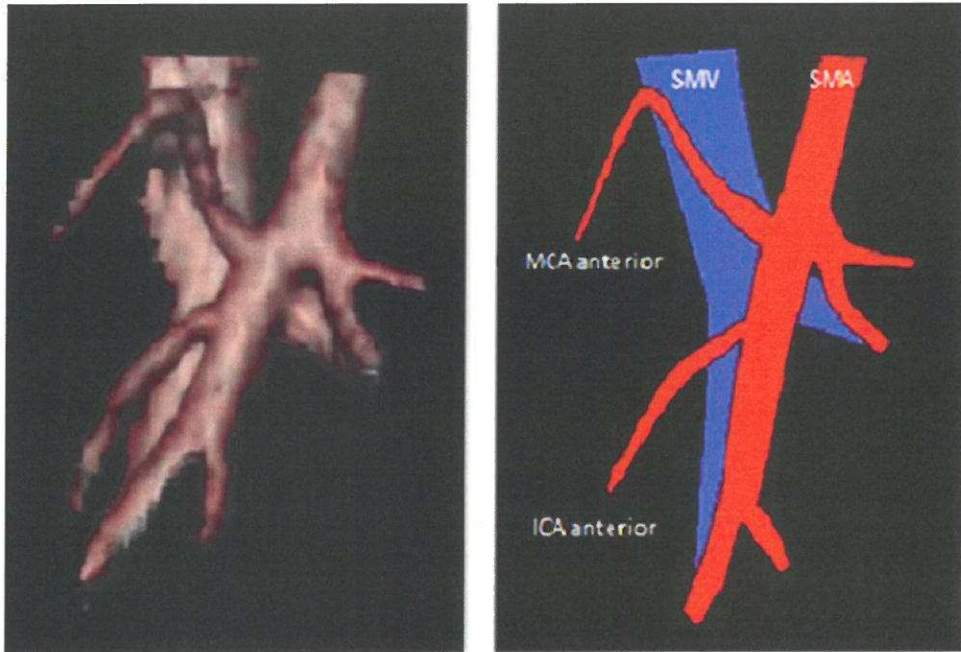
VR image showing middle colic and ileocolic arteries passing anterior to the SMV. Reconstructed from 5mm slice thickness CT scan. Note that although image resolution is poorer than other VR images, vessels can still be easily identified.
